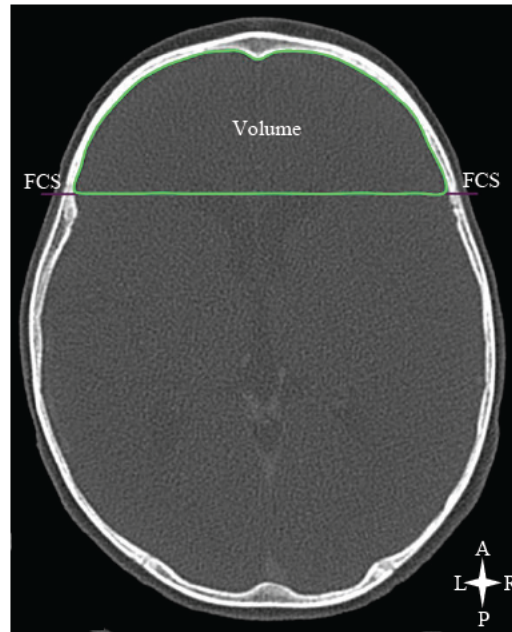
Volume measurement of the ACF on an axial CT scan of a normal patient
